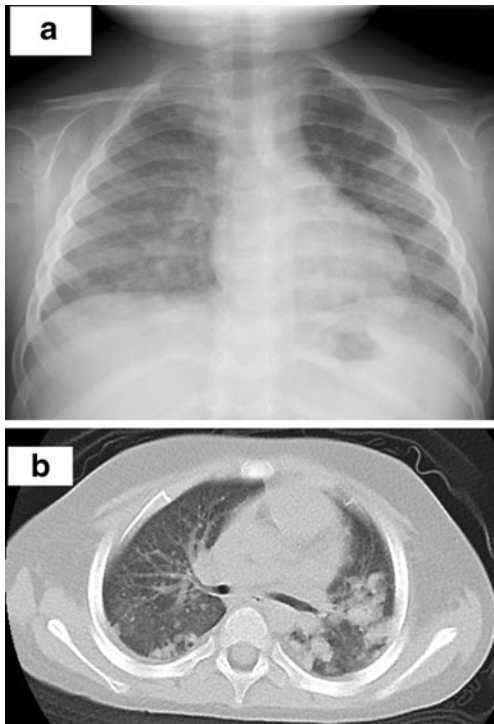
Chest X-ray and high-resolution computed tomography (CT) scan of the lung. a Chest X-ray shows patchy and solid infiltrates spread over both lungs on admission. b A high-resolution CT scan of the chest 3 weeks after admission shows exacerbation of solid opacities in both lobes
